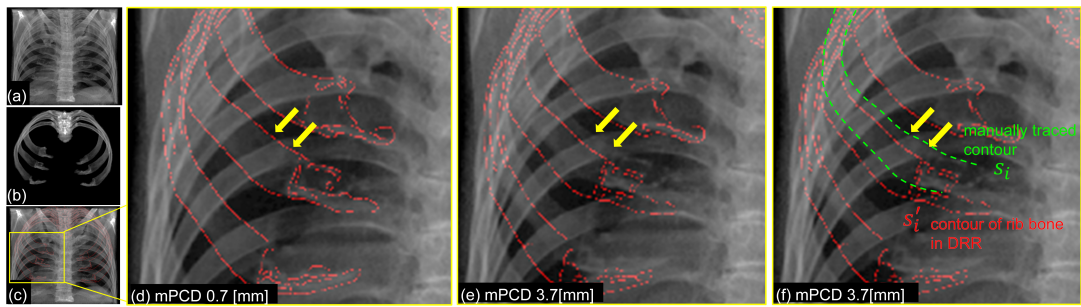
Error metric used in this study, mean projected contour distance (mPCD), and example registration results with different mPCD values. (a) X-ray image, (b) digitally reconstructed radiograph (DRR) at the estimated pose, (c) overlaid with the DRR edges (in red), (d)(e) enlarged view of the trials with different mPCD values. The yellow arrows indicate the true contour of the rib on the x-ray image. The result with mPCD of 0.7 mm (d) exhibits almost no visually recognizable difference between the lines while 3.7 mm (e) shows a clear discrepancy. (f) mPCD was defined as the distance between the manually traced contour (green dashed line) of each rib bone on the x-ray image and the automatically detected contour on the DRR (red dashed line).
